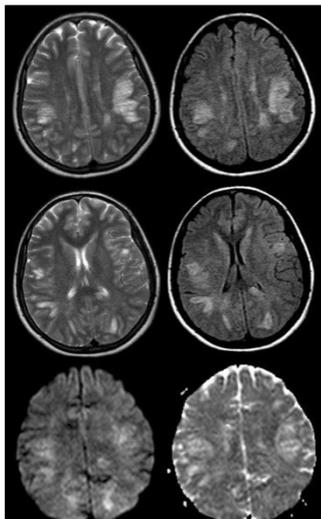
Bilateral, asymmetric, multiple, large T2/FLAIR hyperintensities predominantly involving subcortical white matter of bilateral frontoparietal lobes in a clinically diagnosed case of ADEM
